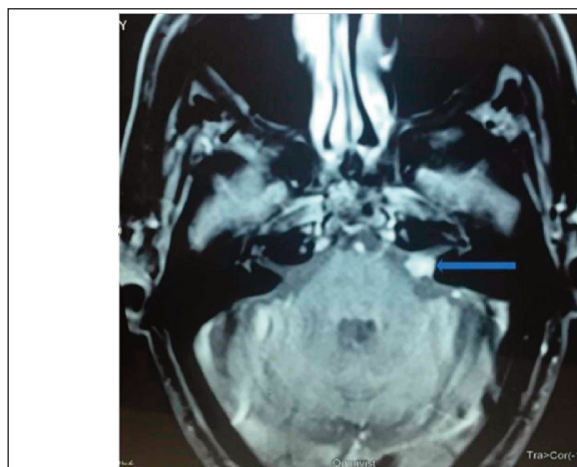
Left vestibular schwannoma. Magnetic resonance imaging (MRI) brain T1-weighted image (T1WI) showing small left vestibular schwannoma.
